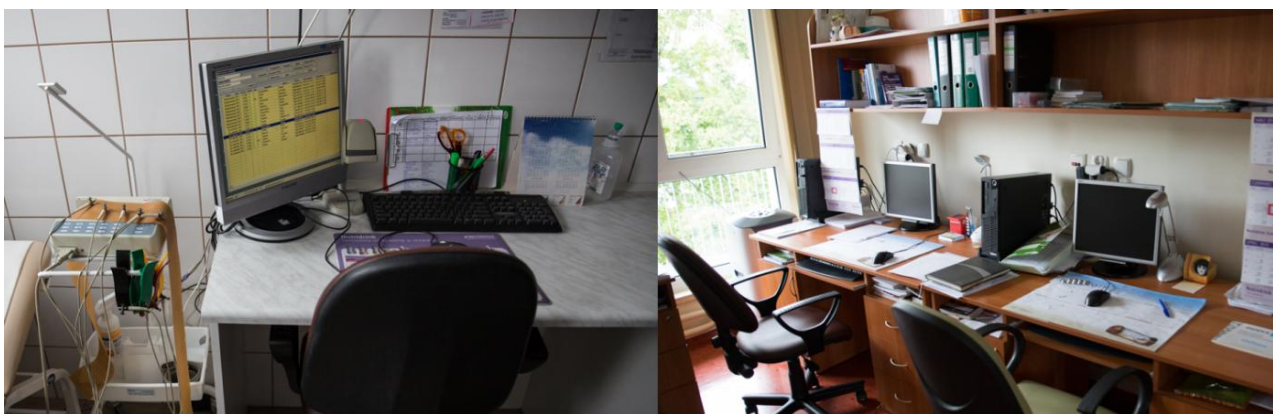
All information about a patient’s treatment history, including tests results and x-ray photos, is managed in the integrated Hospital Information System HIS from InfoMedica. Left: HIS terminal in examination room. Right: HIS terminals in medical oncologist room.
